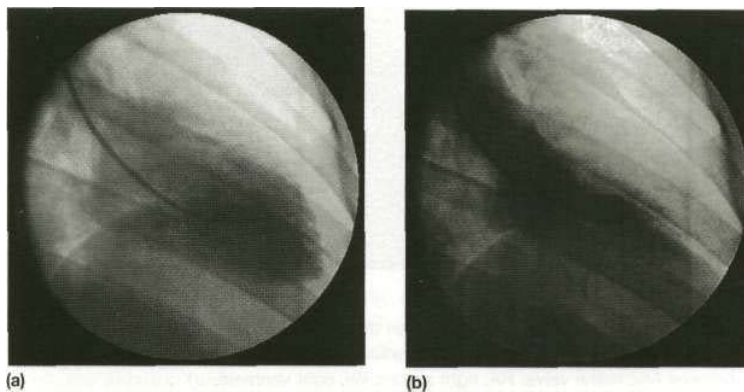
Normal angiogram. Diastolic (left) and systolic (right) frames recorded after X-ray contrast was injected into the left ventricle (contrast left ventriculogram). Normal left ventricular function is demonstrated.
